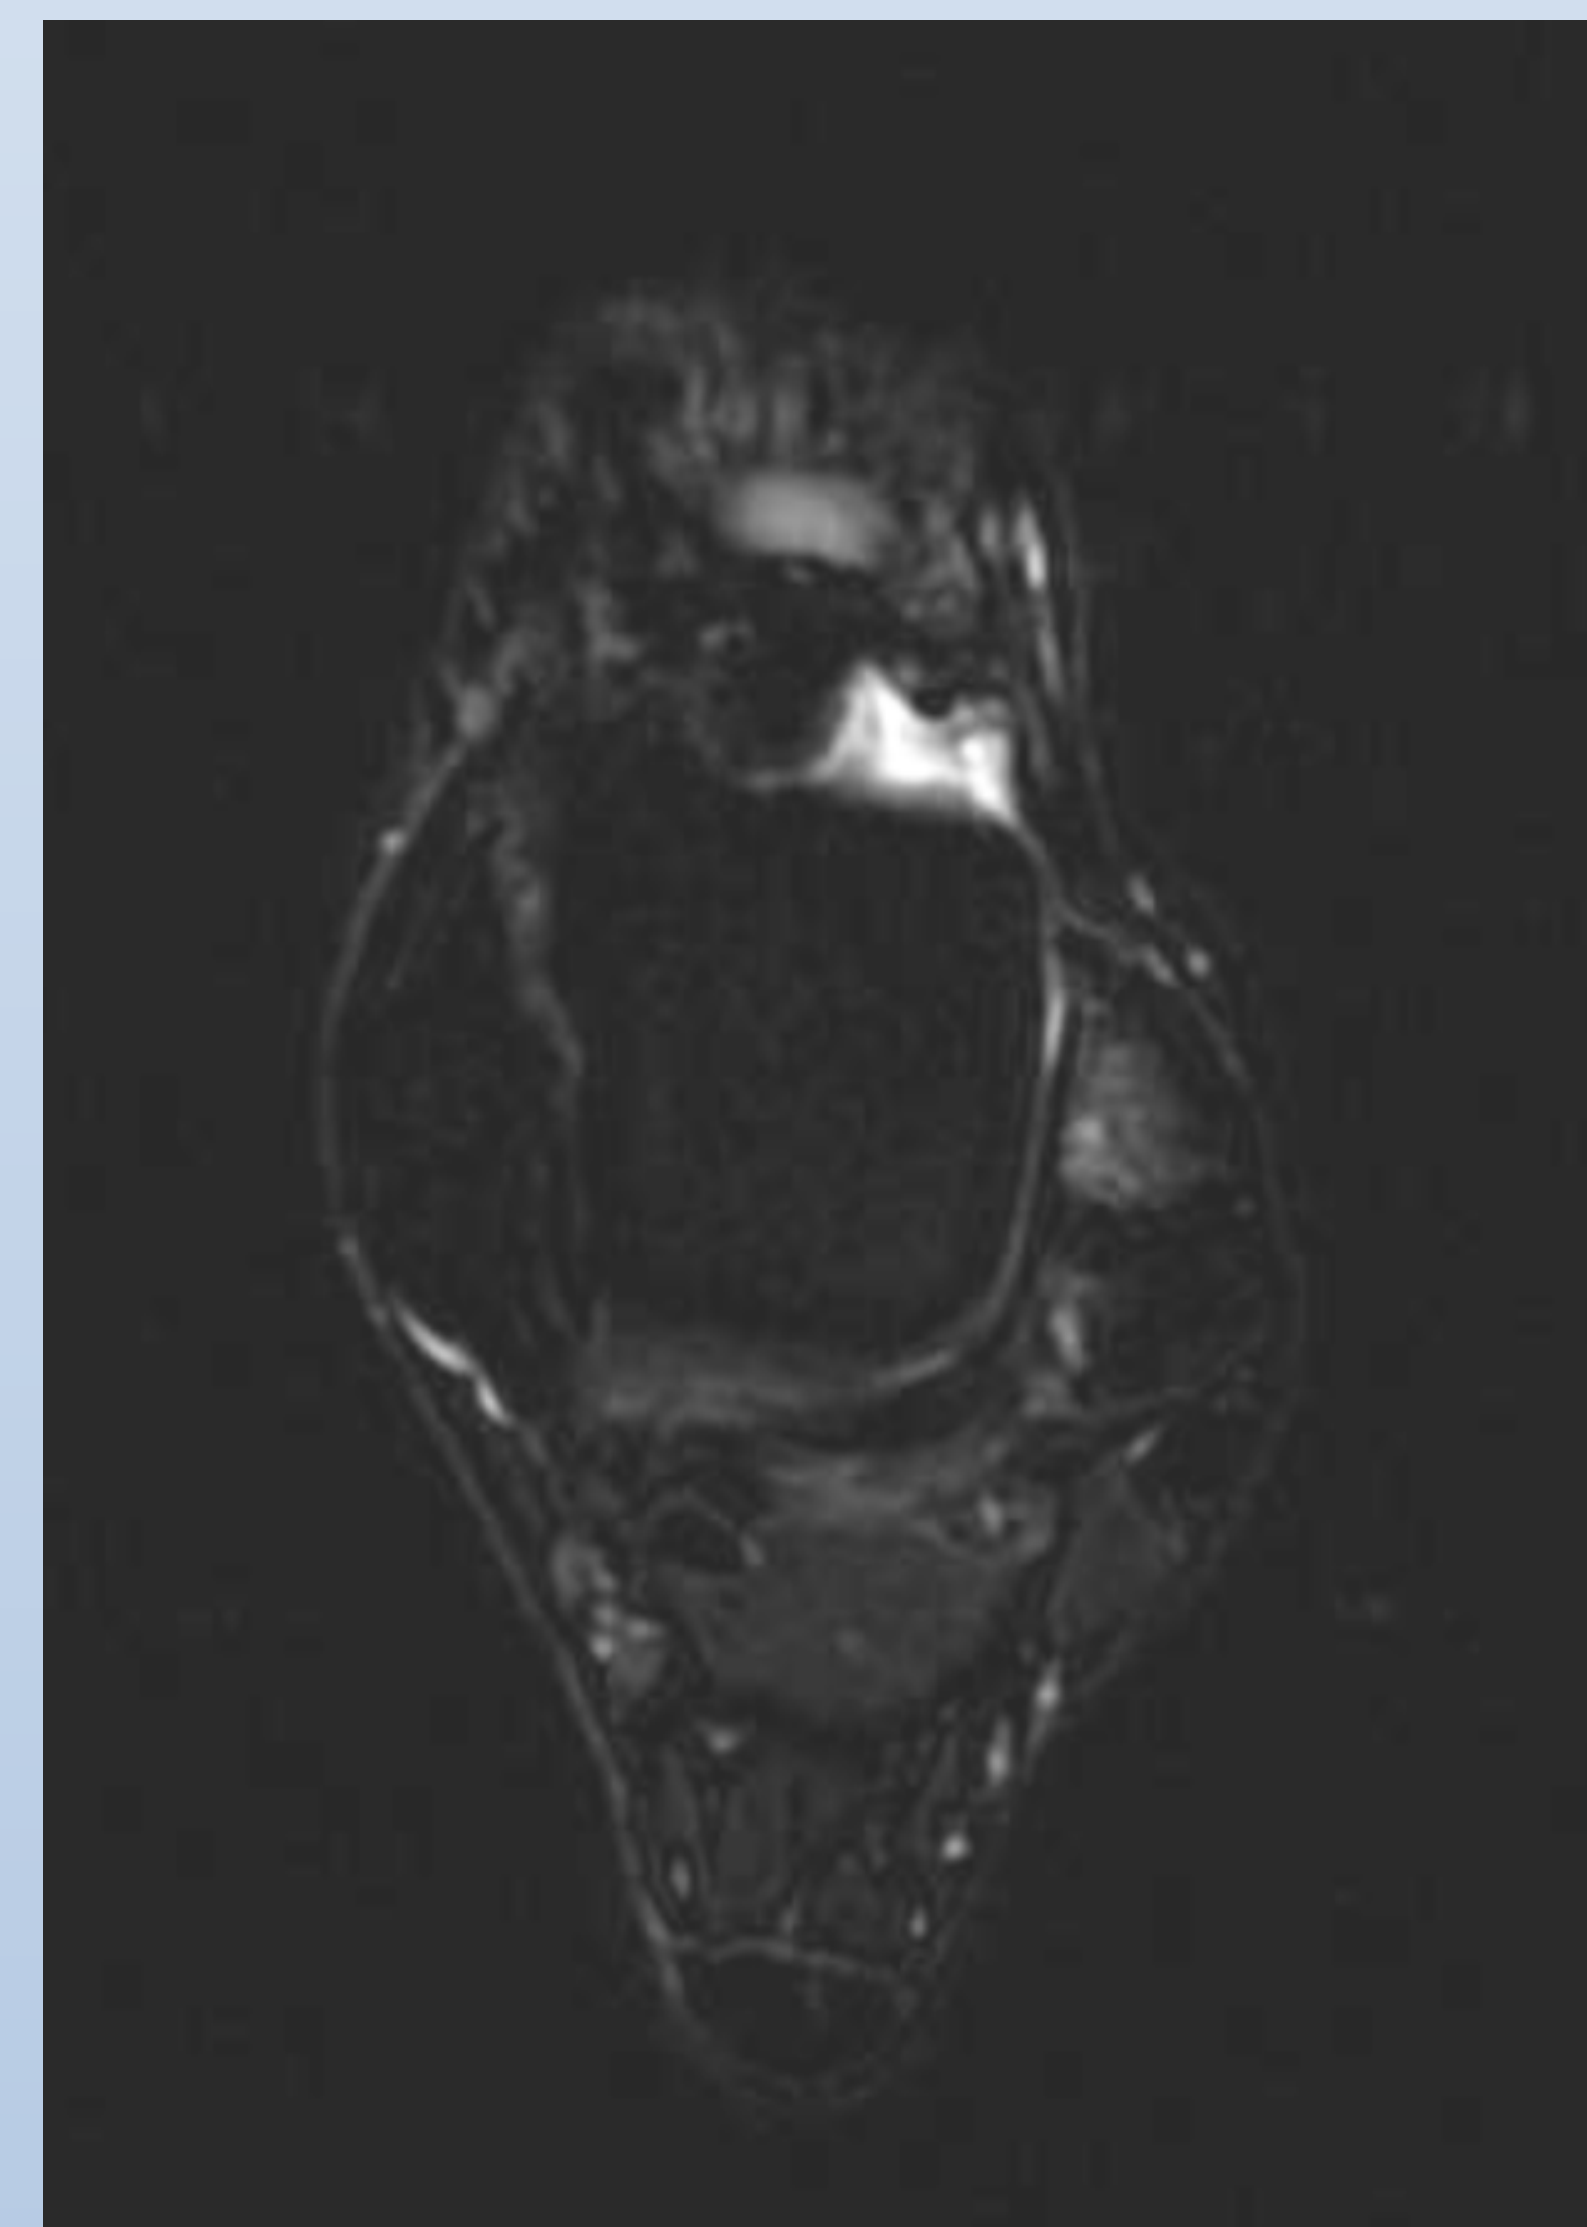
Axial T2 MRI Left Ankle
